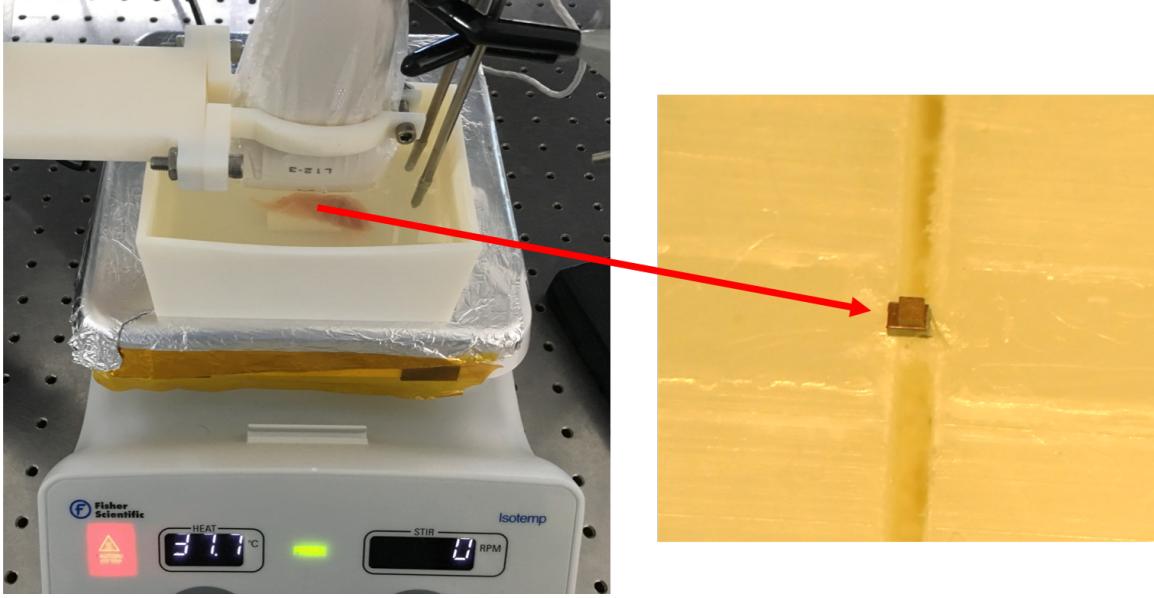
The experimental setup for fully-wireless ultrasound testing with a mote released from the die. Similar to the testing setup for the wire-bonded motes, the standalone mote was mounted on a case and covered with a piece of 3-mm-thick chicken thigh as a biological tissue medium.
